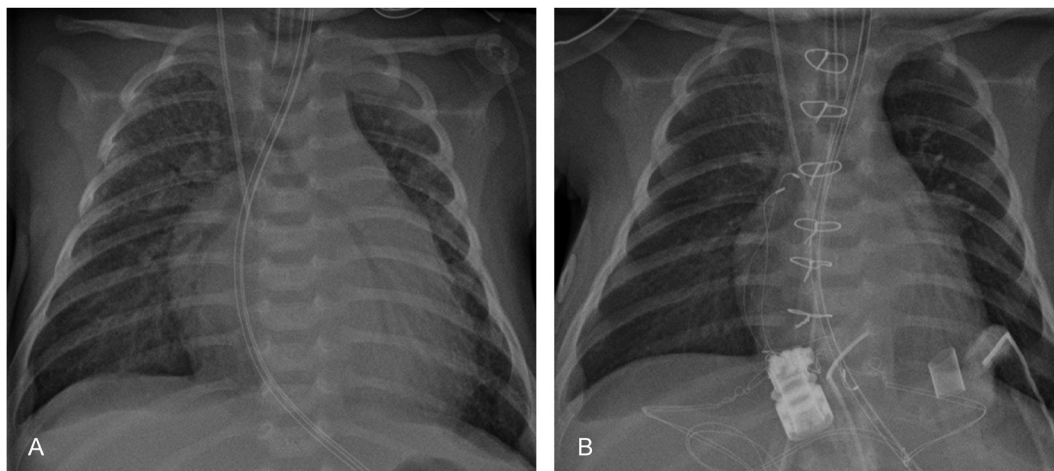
X-ray in a child (1 month) with chronic lymphatic myocarditis with the phenotype of dilated cardiomyopathy and acute heart failure
